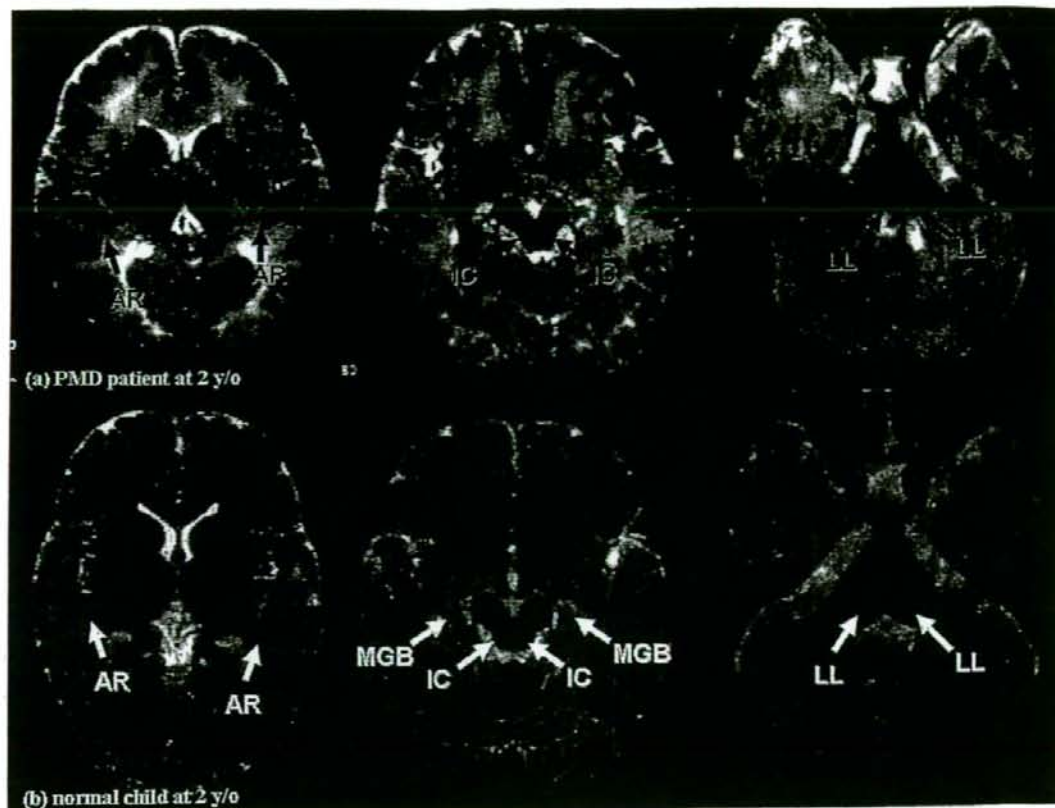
(a) The upper row shows that T2-weighted magnetic resonance imaging (MRI) results of patient 3 at age 2 resemble those of a normal neonate, suggesting that the arrest of myelination occurs soon after birth in PMD. (b) The lower row shows the normal myelination of a young child at age 2. Myelination process reached the auditory radiation. AR, auditory radiation; MGB, medial geniculate body; IC, inferior colliculus brachium; LL, lateral lemniscus.
